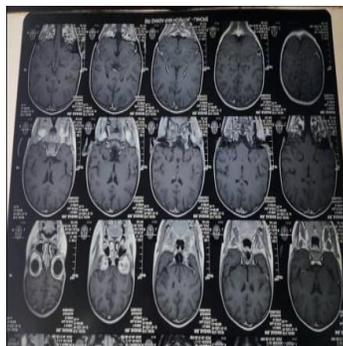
MRI brain with contrast, occasional sites of focal meningeal thickening around right cerebrum, suggesting meningeal inflammation. No intra-axial or brain parenchymal lesion seen otherwise.
